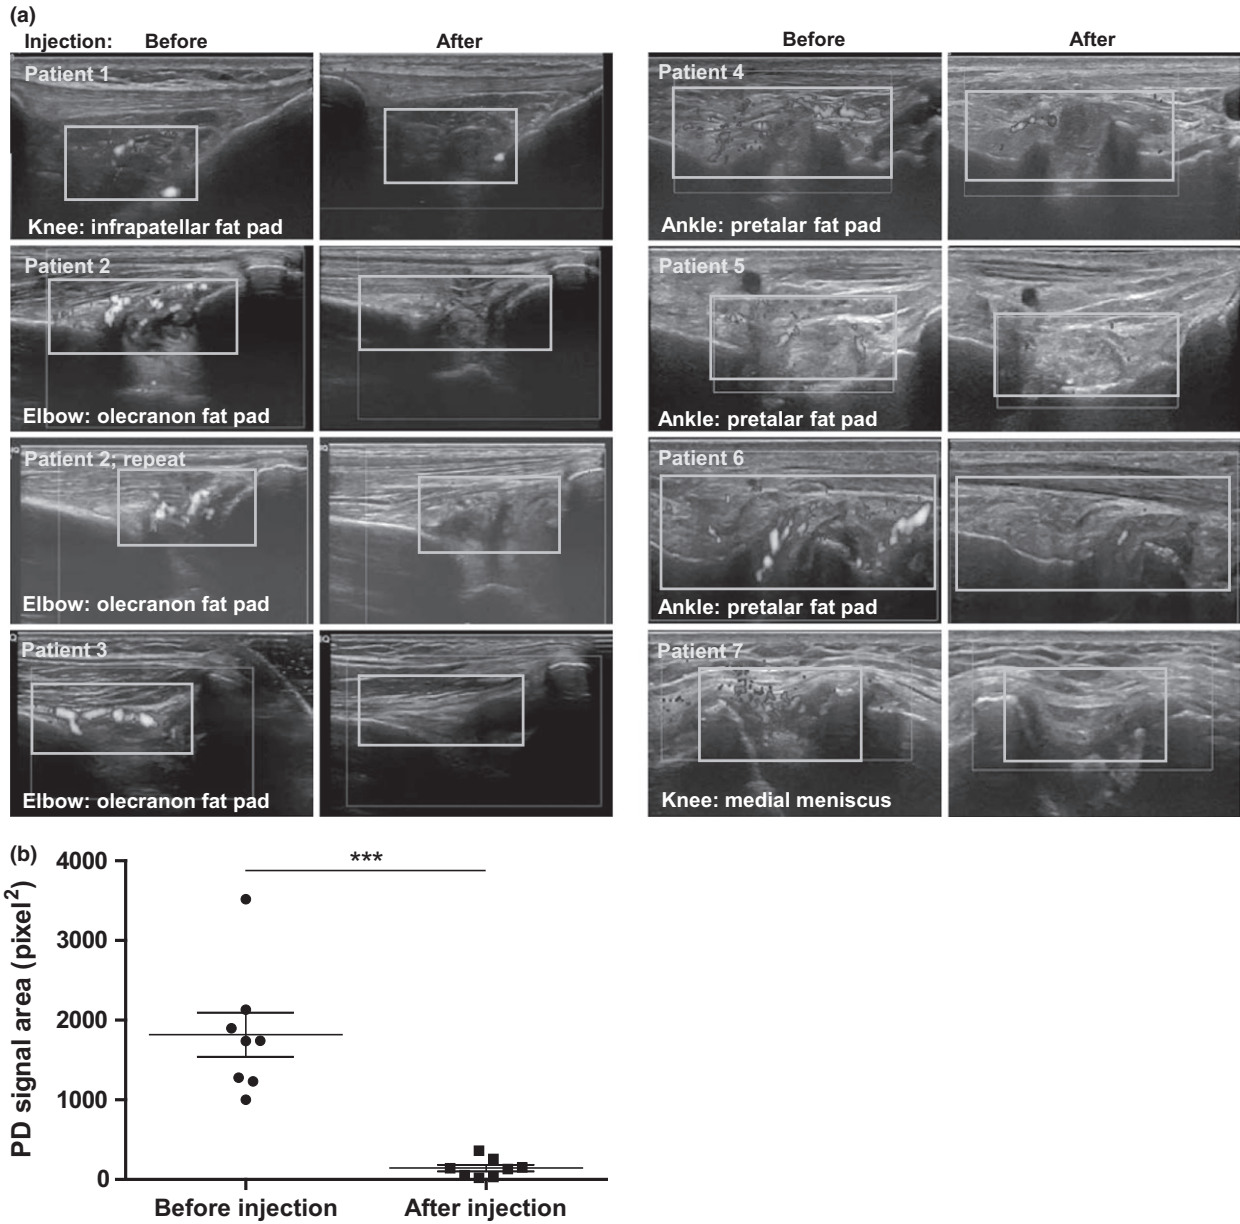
Reduction in vascularity in response to intra-articular corticosteroid injection. Seven patients who underwent intra-articular injection with triamcinolone acetonid (Kenalog[®] 1 mL; 40 mg) and Lidocaine 1% (3–5 mL) returned for re-evaluation 1–4 weeks after injection. Joints were examined by high-resolution musculoskeletal ultrasound with power Doppler. To assess vascularity changes, power Doppler signals were recorded at the time of injection and during re-examination. Patient #2 received a repeat injection 3 months after the first injection, when pain re-occurred. (a) Depiction of joint areas with the most pronounced vascular changes. (b) Quantification of vascularity before and after joint injection using imageJ to determine signal area corresponding to vascular flow. Following all eight injections vascularity decreased remarkably in response to the intra-articular treatment. Notably, the relapse in pain in patient #2 was associated with re-appearance of vascular structures. Error bars represent standard error of the mean, and * denotes statistical significance at $P \leq 0.001$.
